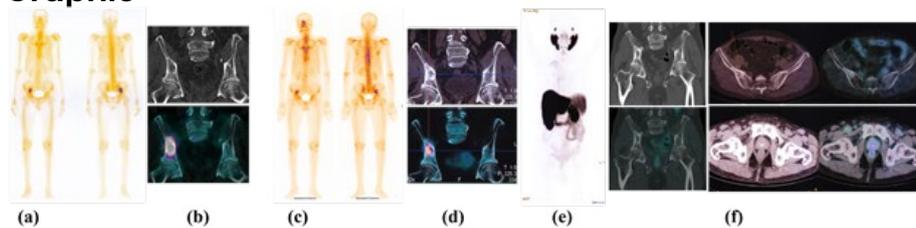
A 60-year-old male with prostate adenocarcinoma (Gleason 3+4=7, initial PSA 58.8 ng/mL), history of TURP, and baseline bone scan (24.02.2024) showing osteoblastic metastasis in the right ilium (a, b). The patient received bicalutamide 50 mg daily, goserelin, palliative radiotherapy to bone, and zoledronic acid. Follow-up bone scan (03.06.2025) demonstrated persistent osteoblastic/sclerotic lesion (c, d). However, ¹⁸F-PSMA PET/CT (25.06.2025) revealed PSMA-negative ametabolic disease in the right iliac bone with low PSMA expression in residual prostatic tissue (e, f), confirming inactive oligometastasis and leading to stage reclassification.
